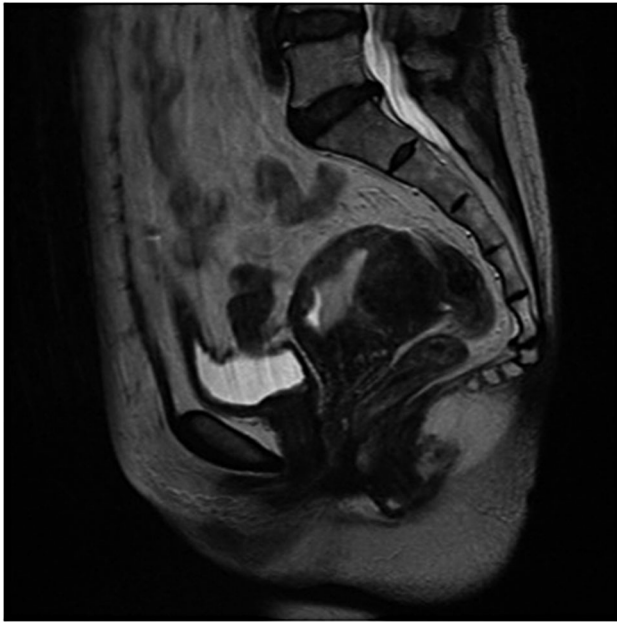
Preoperative T2-weighted magnetic resonance imaging scan (sagittal section) demonstrating endometrial thickening that lacks a sharp endometrium-myometrium interface and posterior myometrial wall thickening suggesting adenomyosis.
